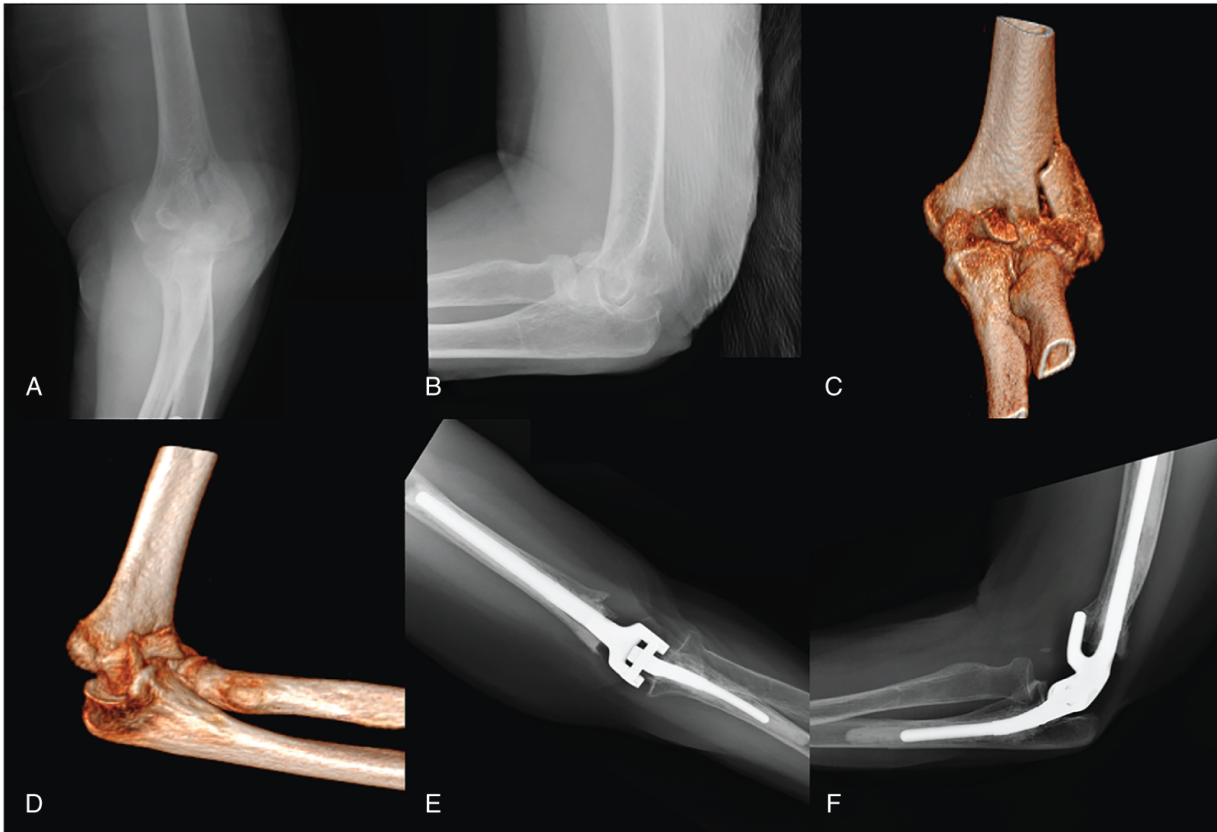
Radiographs and three-dimensional (3D) CT scan reconstructions of an 81-year-old female patient with a comminuted intra-articular distal humerus fracture, including a coronal shear component (A-D). Six-month postoperative radiographs following treatment with a semi-constrained total elbow arthroplasty (TEA) performed through a triceps sparing, para-tricipital approach (E and F).
